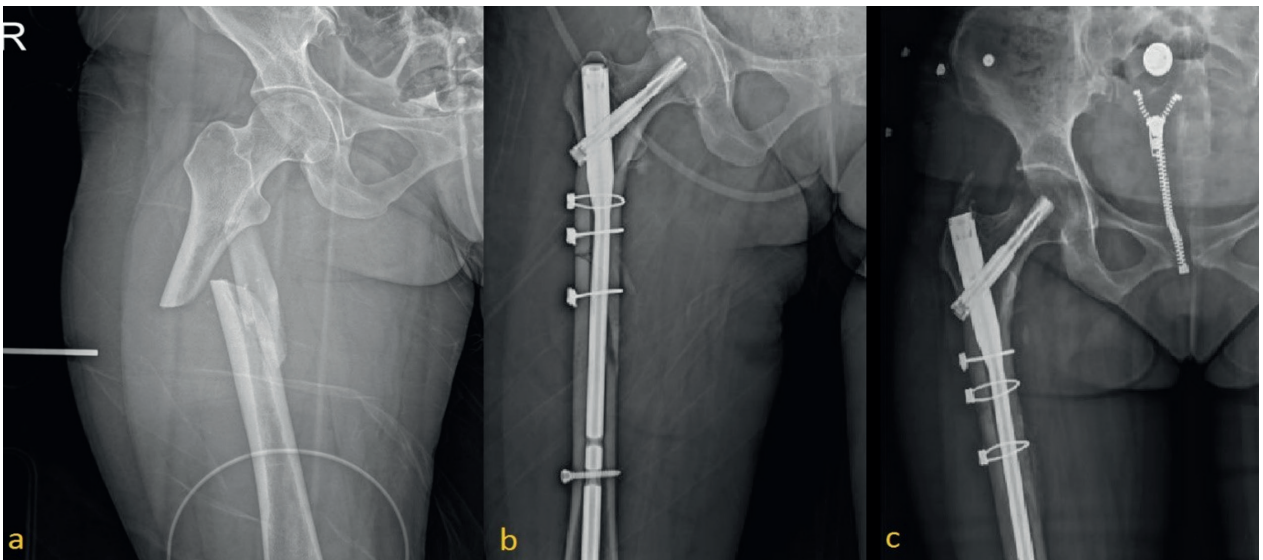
a) 70 years old female patient, motor vehicle accident, preoperative x-ray. b) Postoperative 7th month x-ray, 7mm gap laterally and 6 degrees of varus deformity. c) 6th month x-ray after revision surgery with cable use, complete union.
